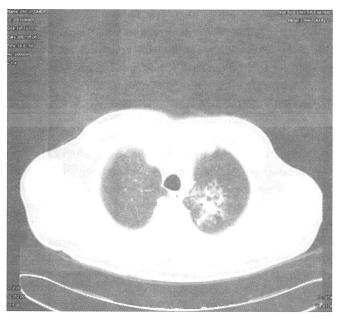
Parenchymal infiltration in the left upper lobe on HRCT of thorax.
